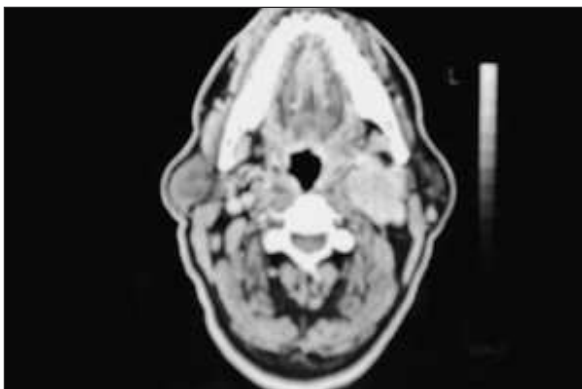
Contrast computed tomography scan showing an enhancing left neck mass in the region of the carotid bifurcation.
